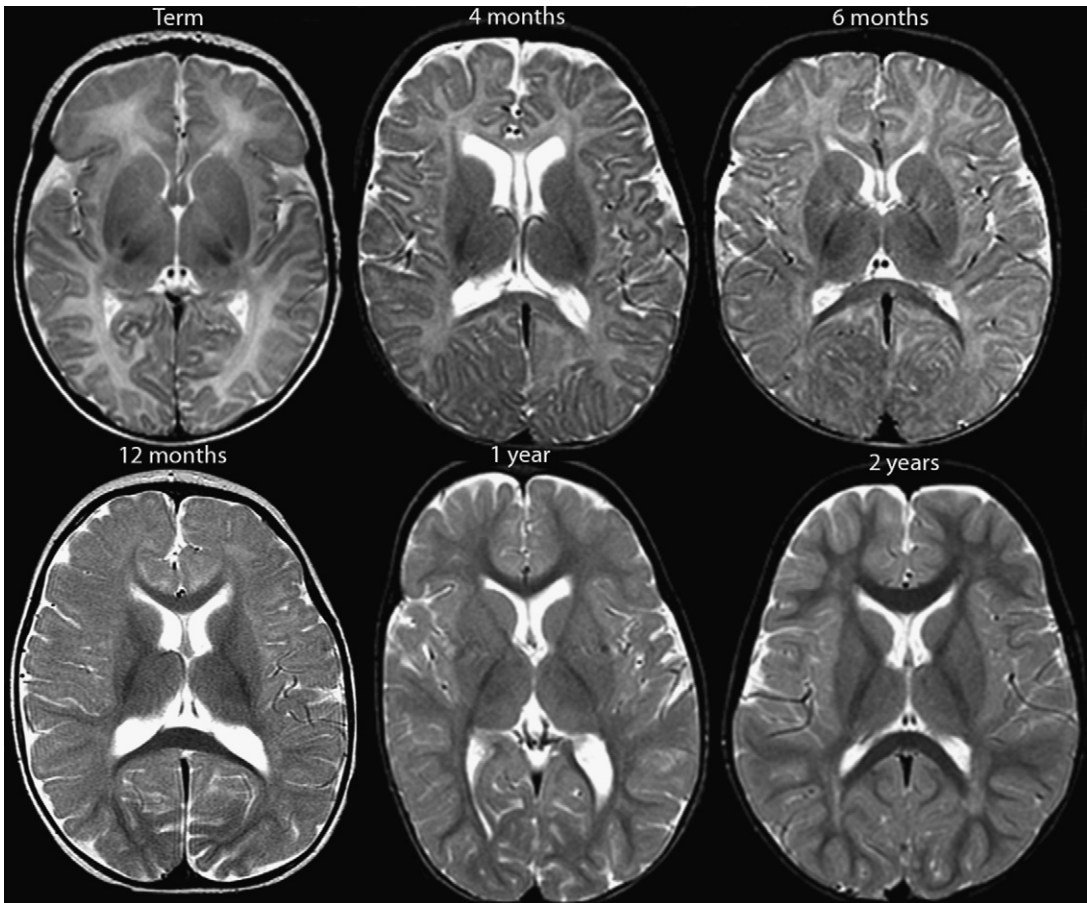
Summary slide of progression of normal myelination. Progression of normal myelination on MR imaging from birth (term) to 2 years of age on a T2-weighted sequence.
